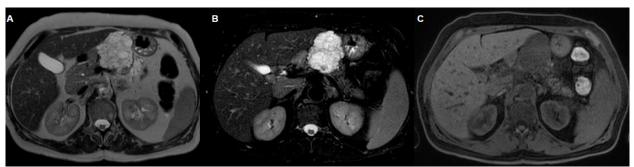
Abdominal MRI of serous cystadenoma
